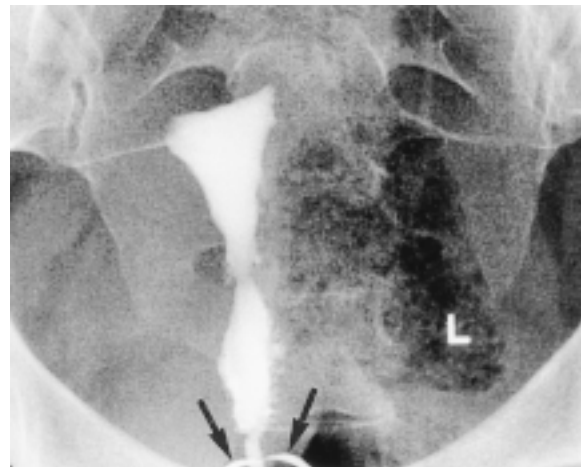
Pelvic radiograph demonstrates a tenaculum on the cervix (arrows). This device can also be used to help straighten the uterus for tubal catheterization.
